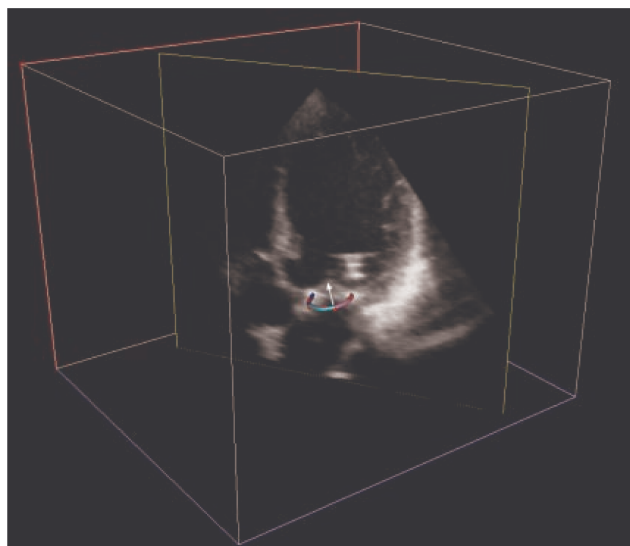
Example of a cut plane from a transthoracic RT3DE, obtained in a patient after annuloplasty, with the 3D reconstruction of mitral annulus superimposed.
